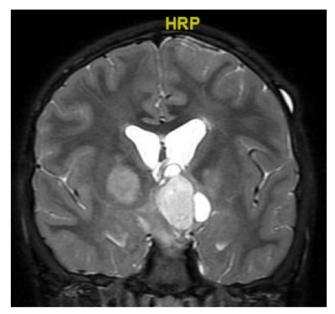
A 10-year-old boy with a large OPG obstructing the foramina of Monro. Coronal T2-weighted images. The child underwent a septostomy and a shunt. Over the years, he underwent various chemotherapy treatments, and eventually a subtotal resection of the tumor (which was a pilocytic astrocytoma)
